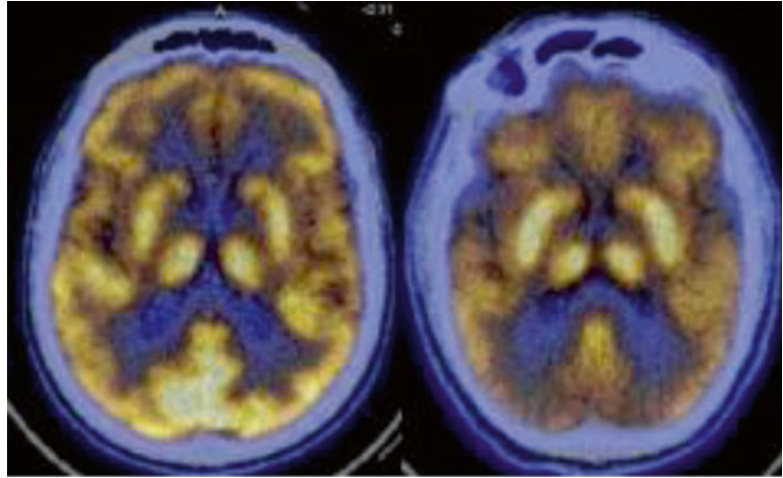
Transaxial fused F-18-FDG PET-CT image (*left*) of a case of MSA-C; hypometabolism is noted in both basal ganglia posteriorly and in both cerebellar hemispheres (*right*)
